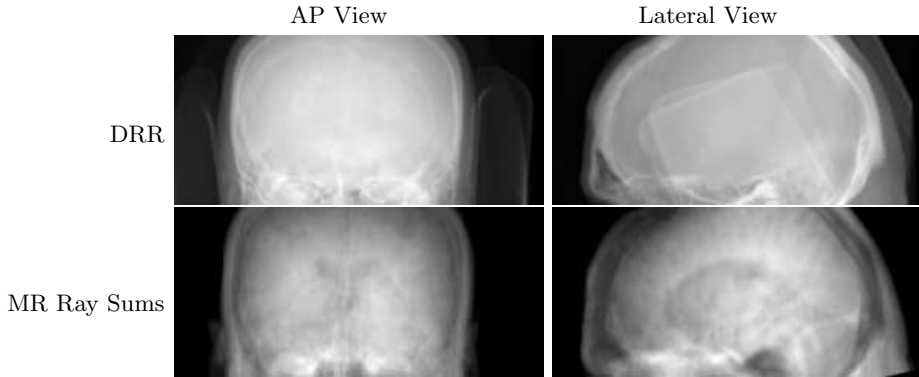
DRR images (*top row*) and spatially equivalent MR ray sum images (*bottom row*). The 3-D CT and MR image were aligned using an intensity-based rigid-body image registration algorithm.
